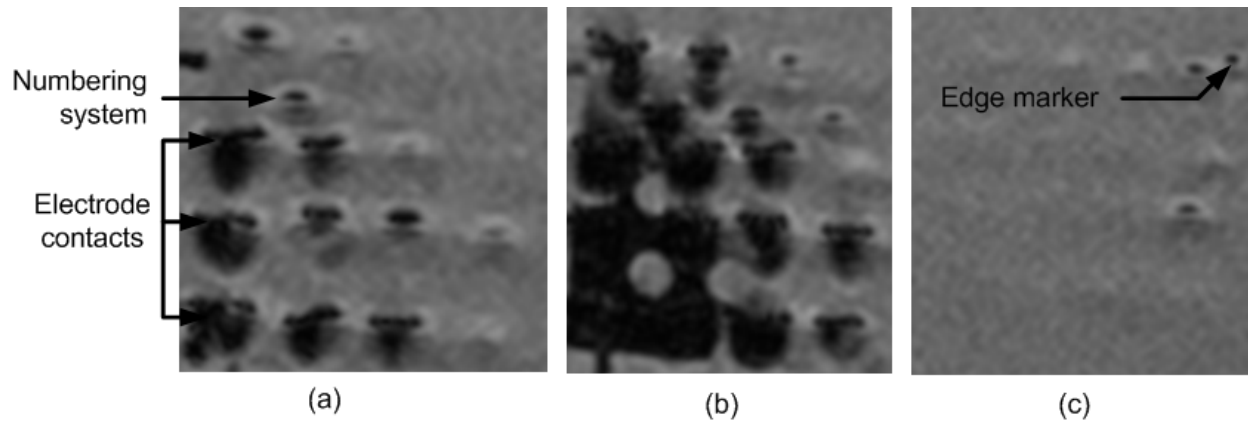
MRI image sequences of the new mini-grid Pt electrodes: Images (a) – (b) were taken by placing the electrodes into a gel solution (0.9% NaCl with 14gm gelatin) and scanning them using a 1.5 T Phillips MR scanner.
